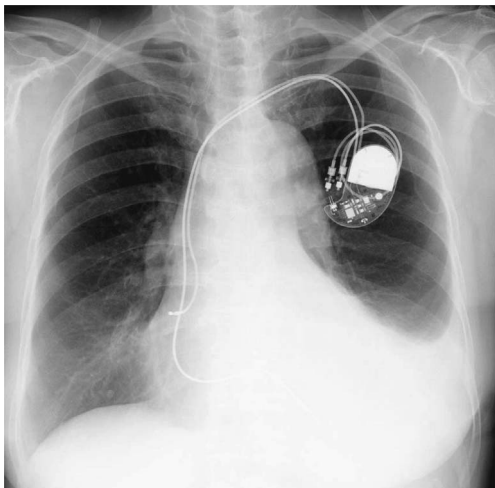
Chest X-ray at discharge. Pleural effusion was found to have decreased.
